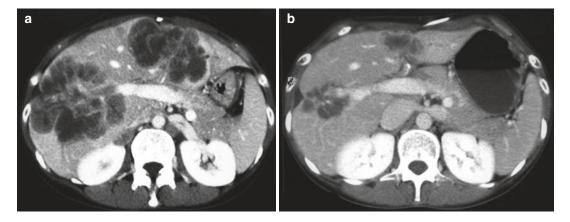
Results of chemotherapy: CT scan demonstrating. (a) Tumor burden prechemotherapy treatment; (b) tumor burden postchemotherapy treatment
